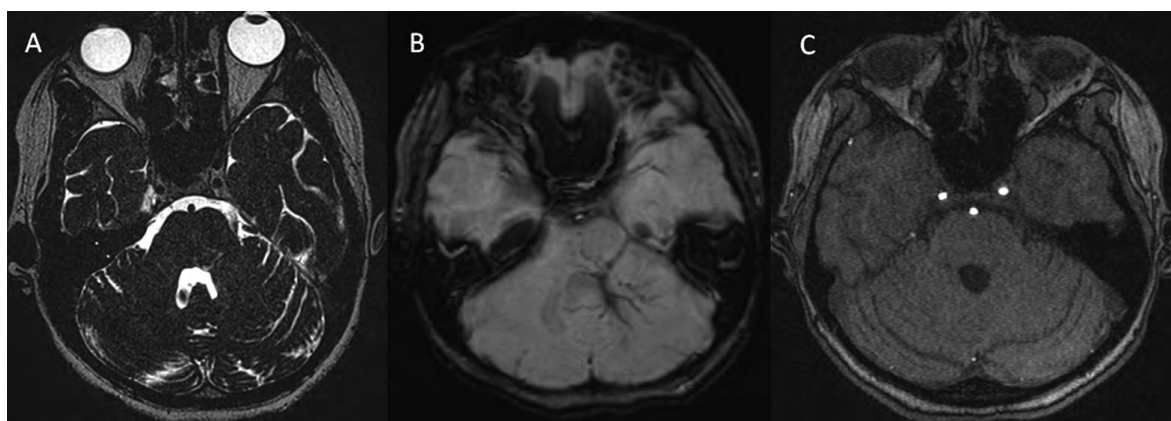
MRI findings in Case 1: A – 3D-DRIVE image showing a dilated venous structure in the left cerebellopontine angle adjacent to the root entry zone of the left trigeminal nerve; B – SWI demonstrating a dilated vein in the left middle cerebellar peduncle and a “caput medusae” pattern in the left cerebellar hemisphere and pons; C – 3D-TOF MR angiography showing no arterial neurovascular conflict around the left trigeminal nerve. Source: created by the authors
